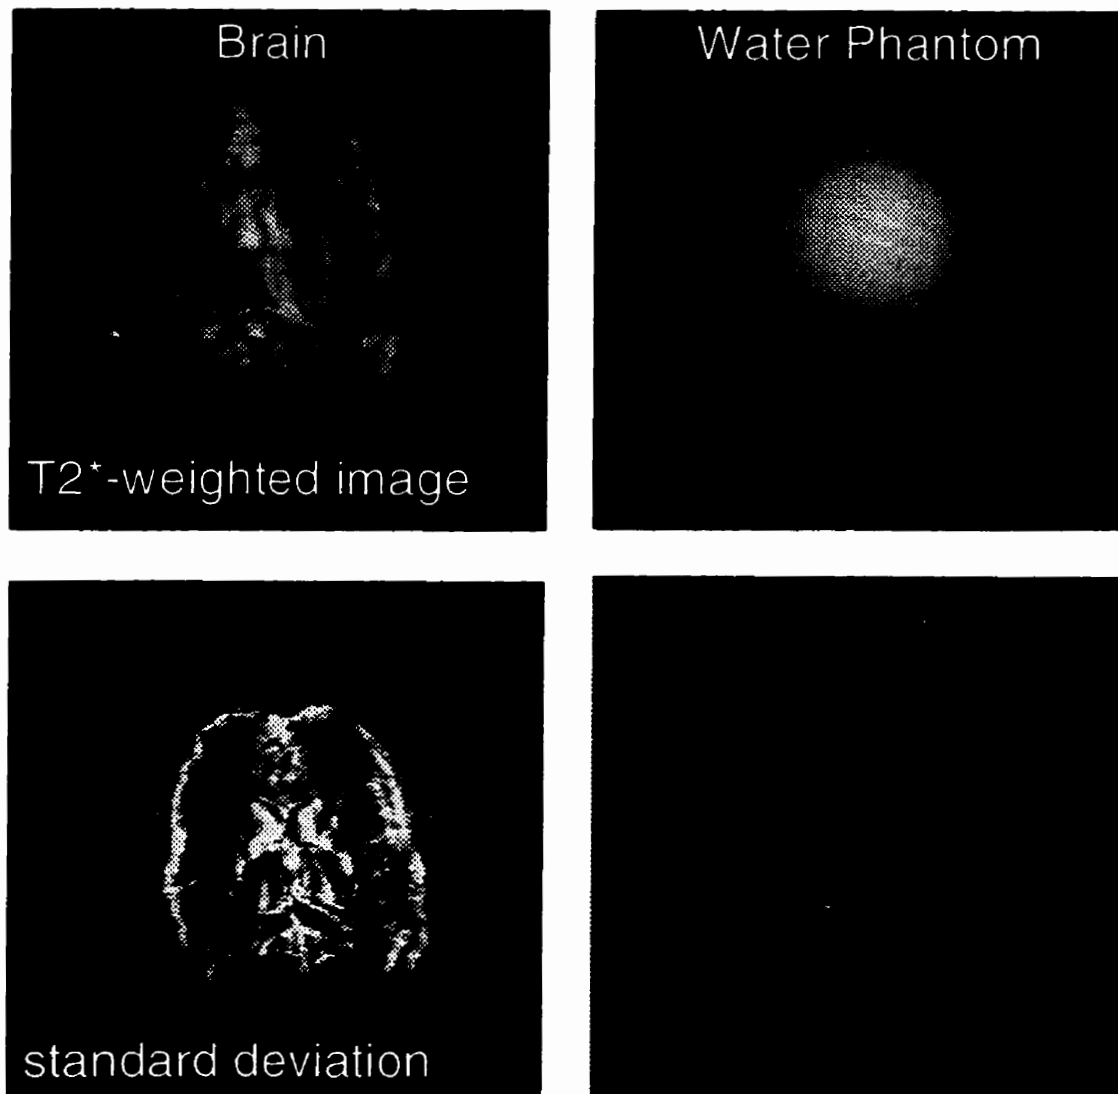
Instability in FLASH MR images of living brain vs. water bottle. Standard deviation images represent the standard deviation of signal in each pixel over a time course of images. Brain images show signal variations up to 100 times greater than the intrinsic noise of the experiment.
